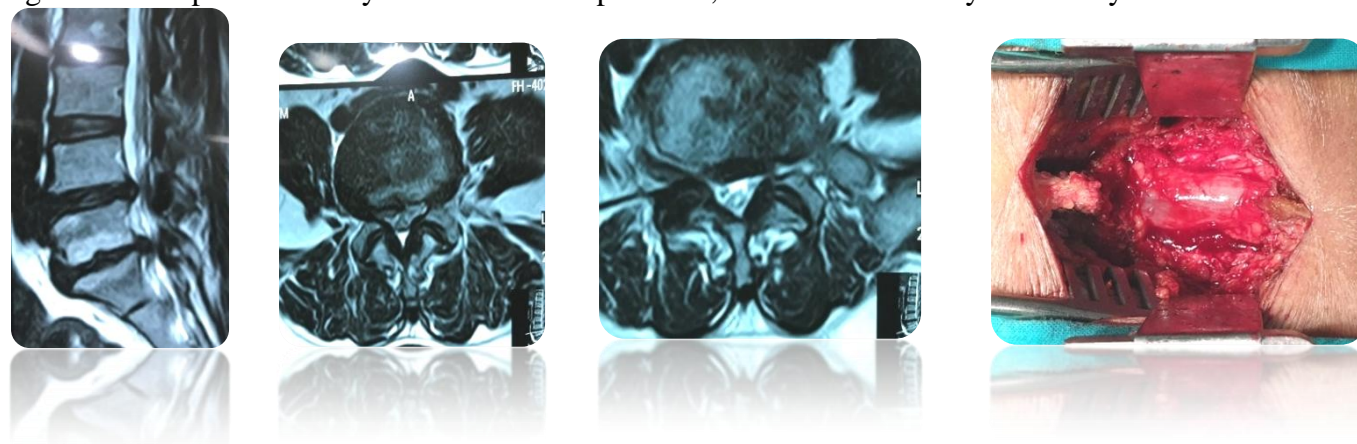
Pre-operative MRI of lumbosacral spine sagittal and axial sections T2 weighted image with operative image of the operative site showing L5 laminectomy.
